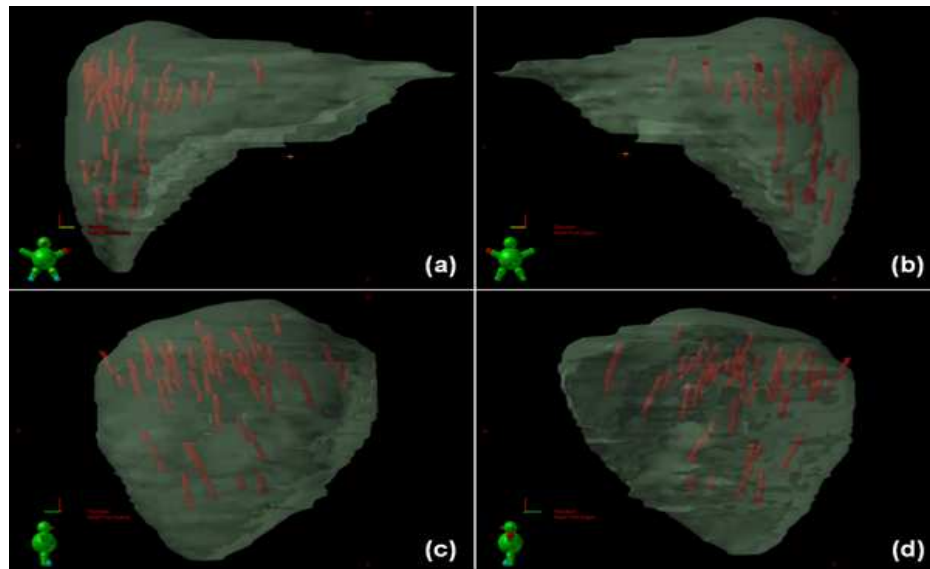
Trajectories of all 49 markers reconstructed, during their 1st fraction CBCT scans, viewed from the (a) anterior, (b) posterior, (c) left, and (d) right beam's eye view.
